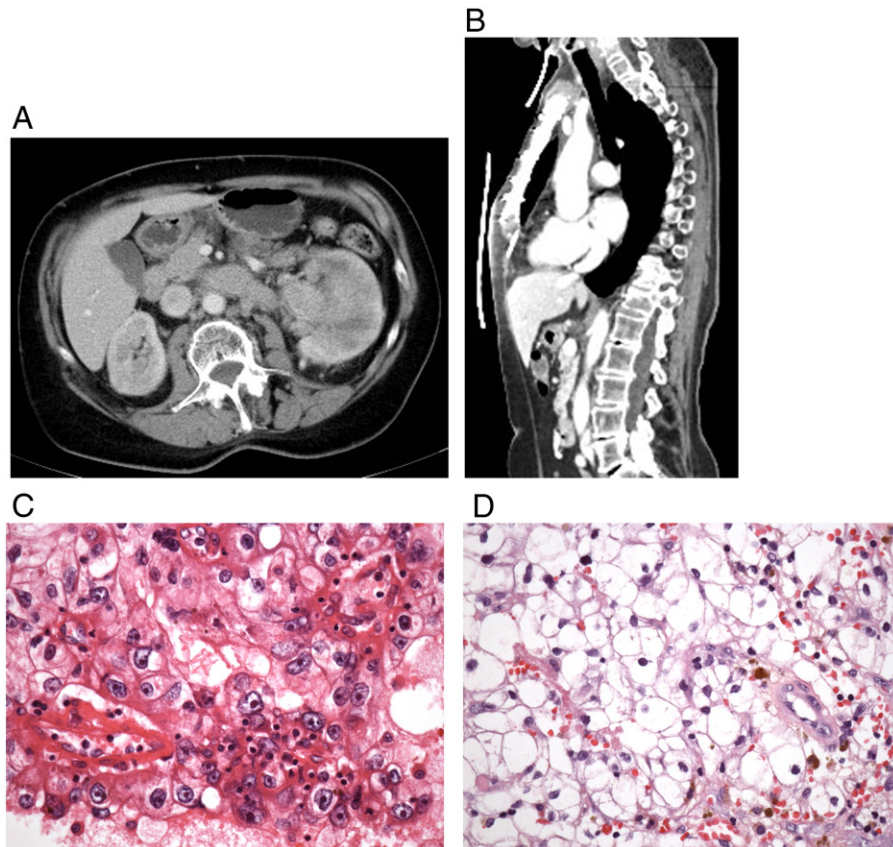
Patient number 4: computed tomographic scans showing a large tumor mass with vein invasion in the left kidney (A) and vertebral metastases (B). Clear cell renal cell carcinoma was Fuhrman grade 3 in the primary tumor (C) and Fuhrman grade 1 in the metastases (D).
